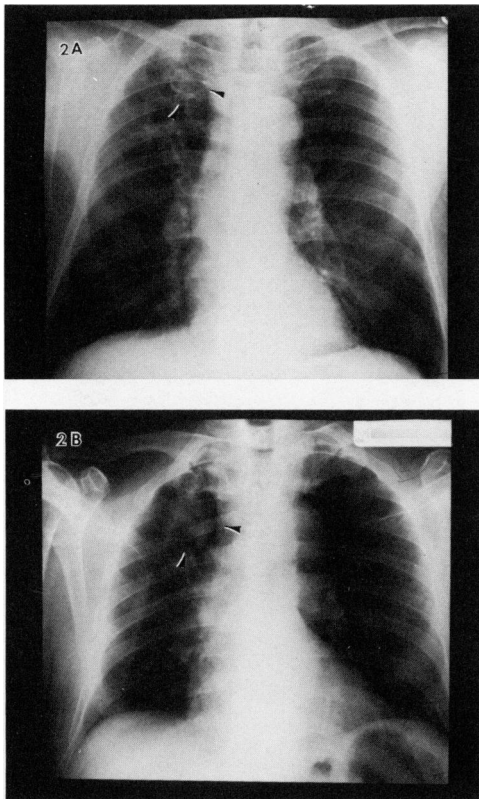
A. Chest radiograph obtained in September 1978 showing a small right upper lobe cavitary lesion (*arrow*). B. Subsequent film obtained in August 1983 showing a large right upper lobe mass lesion (patient No. 2).
